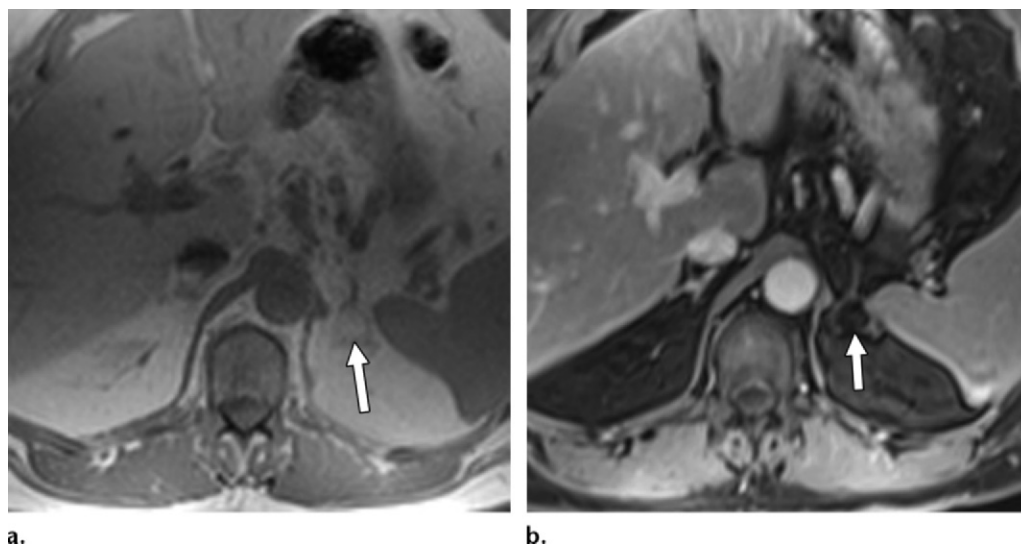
Adrenal AML in a 49-year-old woman. Axial nonenhanced (a) and fat-suppressed gadolinium-enhanced (b) T1-weighted MR images show a right adrenal mass (arrow). The mass shows high T1 signal intensity, with signal intensity loss seen on the fat-suppressed T1-weighted image. There is a thin peripherally enhancing capsule and minimal enhancement of the fatty tumor.
